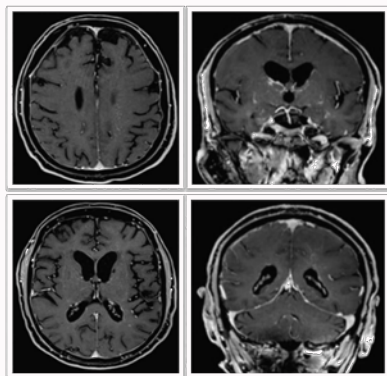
Coronal and transversal post-gadolinium brain MRI: *Prominence of vascular structures, which may correspond to deep veins, and pose the possibility of some type of vasculitis, including granulomatous angiitis or even angiocentric lymphoma.*
